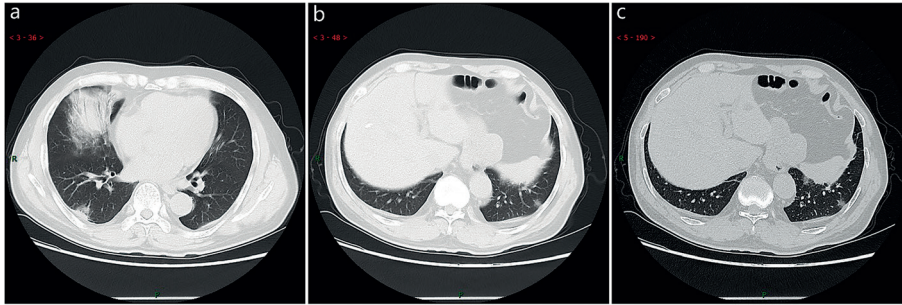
Typical CT / X-ray imaging manifestation (case 3). A 65 years old male with fever for 4 days (38.7 °C). Laboratory test: normal white blood cells ($3.72 \times 10^9/L$), decreased lymphocytes ($0.9 \times 10^9/L$), decreased eosinophil count ($0 \times 10^9/L$), increased C-reactive protein (53.0 mg/L), increased procalcitonin (0.10 ng/ml), reduced liver function, hypoproteinemia, and mild anemia. Imaging examination: a and b showed large consolidation in the right middle lobe, patchy consolidation in the posterior and basal segment of the right lower lobe, with air-bronchogram inside, c showed patchy consolidation in the outer and basal segment of the left lower lobe, and a small amount of effusion in the right chest
